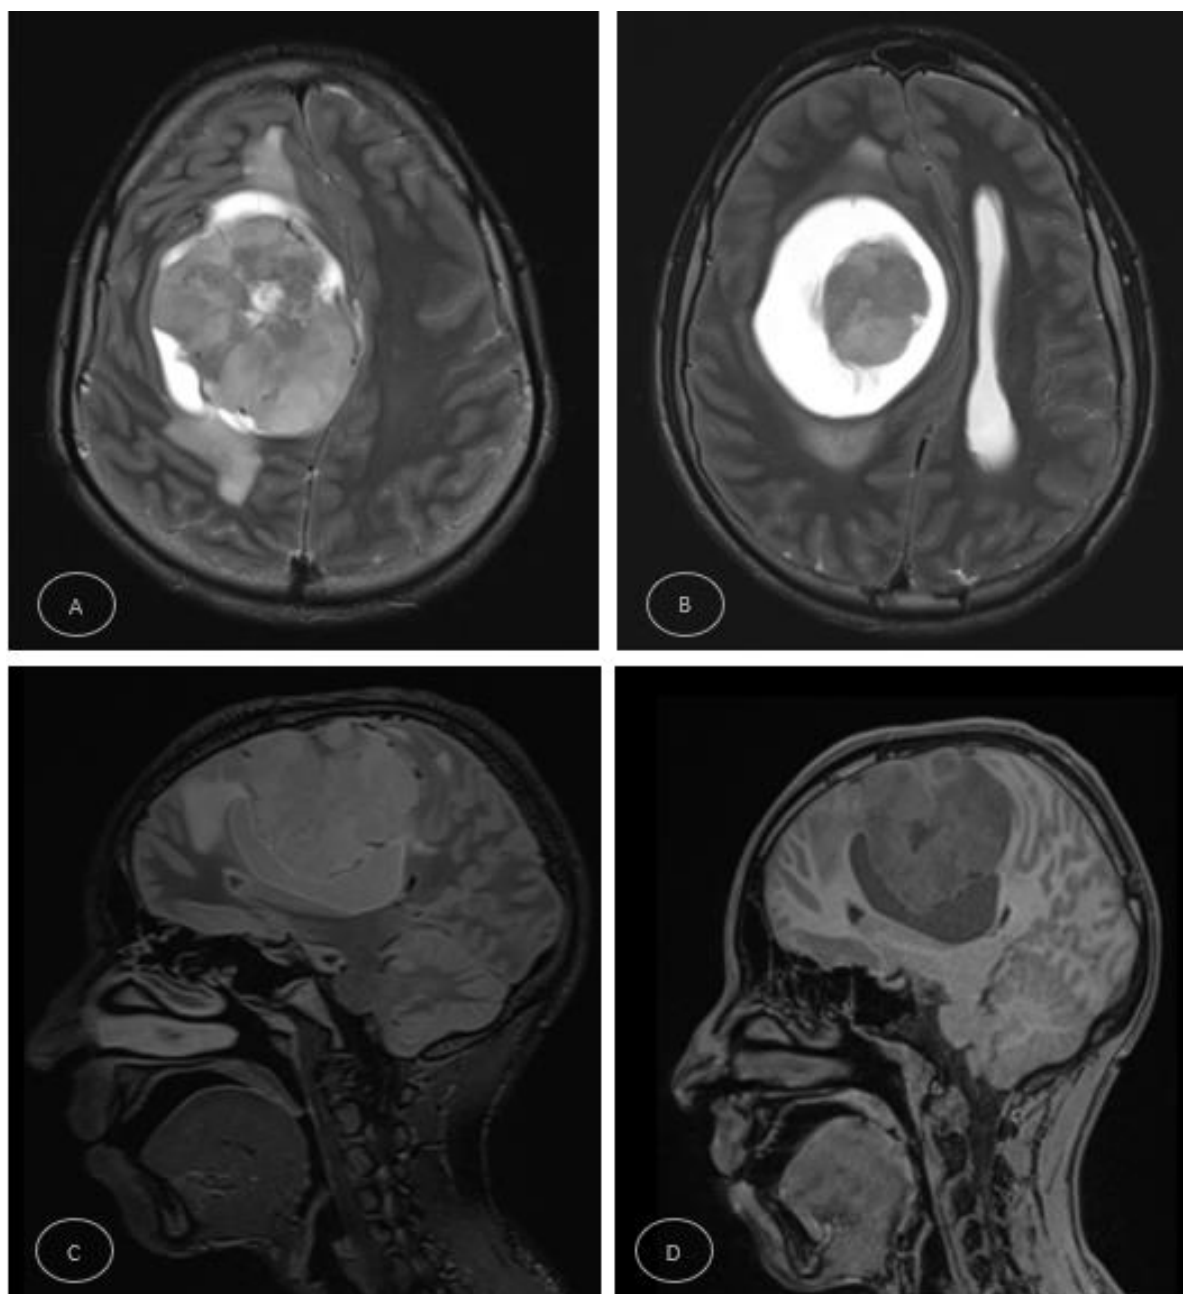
(a and b) Axial T2-weighted images show a giant multilobulated right frontal convexity extra-axial mass with solid and cystic components, severe mass effect, and contralateral ventricular dilatation. (c) Sagittal fluid-attenuated inversion recovery and (d) sagittal T1-weighted images demonstrate the inferior peritumoral cyst located between the tumor and compressed frontal lobe, supporting a Nauta type IV configuration.
